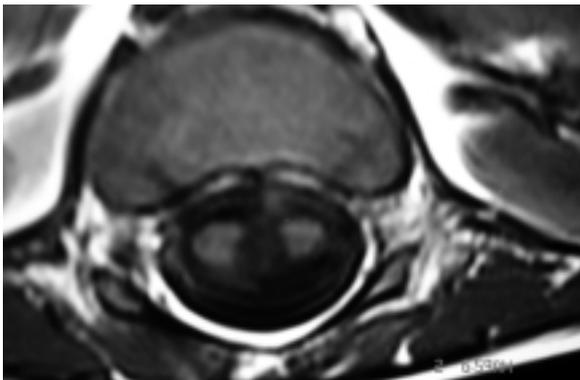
MRI axial section showing two hemicords divided by a bony spur.
